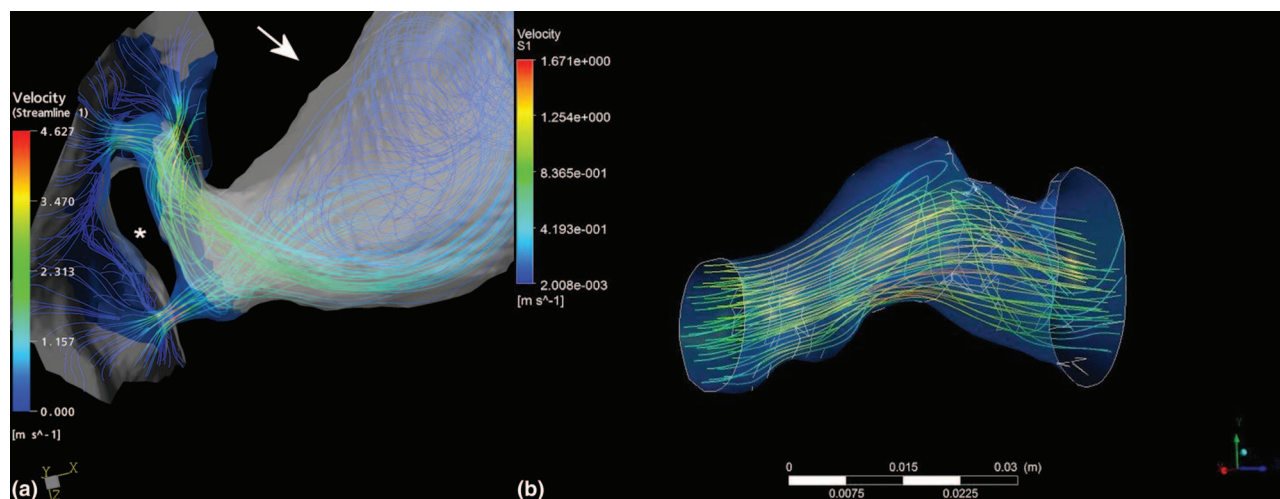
Computational fluid dynamics modeling. (a) Streamlines across an ostial renal artery stenosis (complex high-grade stenosis indicated with white asterisk). Vessel segmentation was based on thin-section contrast-enhanced CT angiography. Note the vortices formed (arrow) after the high-grade stenosis. Reproduced with permission from Kagadis *et al.*, *Medical Engineering & Physics* 30, 647–660 (2008). Copyright © 2008 Elsevier. (b) Streamlines in a segmented OCT acquired femoral artery. CFD mathematical models may be overlaid on three-dimensional anatomical models produced by CT, OCT, or MR to combine morphology with function during image-guided therapies. Hemodynamic parameters produced by CFDs may aid treatment planning and execution by pin-pointing areas of disturbed blood flow that have been linked to increased risk of thrombosis or restenosis after treatment. Direction of the flow is from left to right in both image parts.
